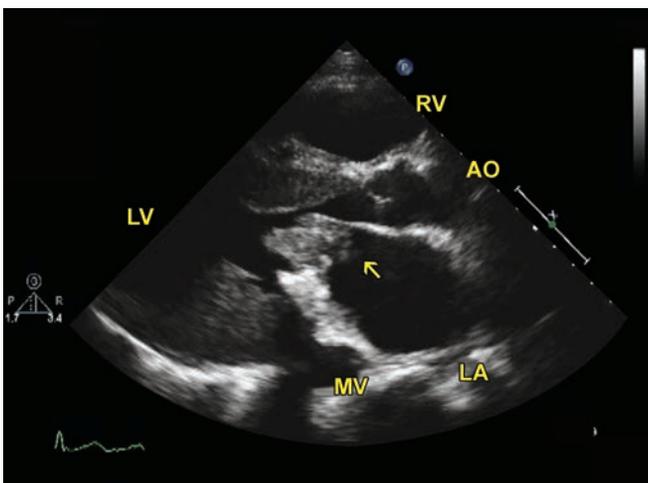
TTE parasternal long axis view showing a large mobile echo density mass (arrow) attached to the anterior leaflet of the mitral valve on the atrial side, measuring 33 mm \times 20 mm). Also, note the severe left ventricular hypertrophy due to long-standing uncontrolled hypertension and end stage kidney disease.
